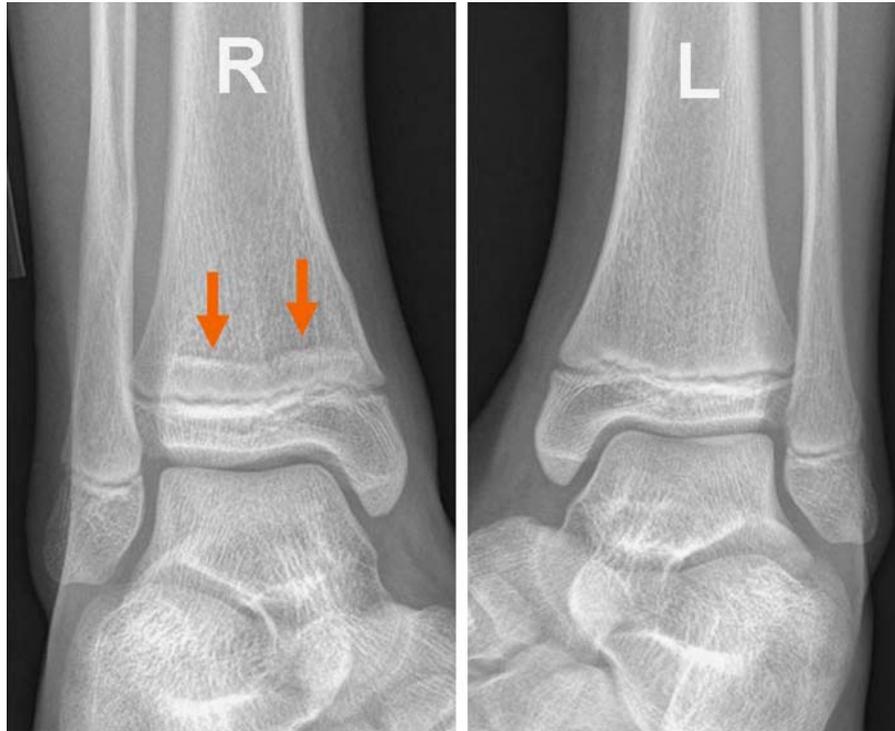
Anteroposterior radiographs of bilateral ankles at the 16-month follow-up clinic visit. The physis of the injured ankle on the right is open without any evidence of physal bar formation or closure. Also, note the metaphyseal scar (arrows) of the previous injury seen about 7 mm above the physis.
